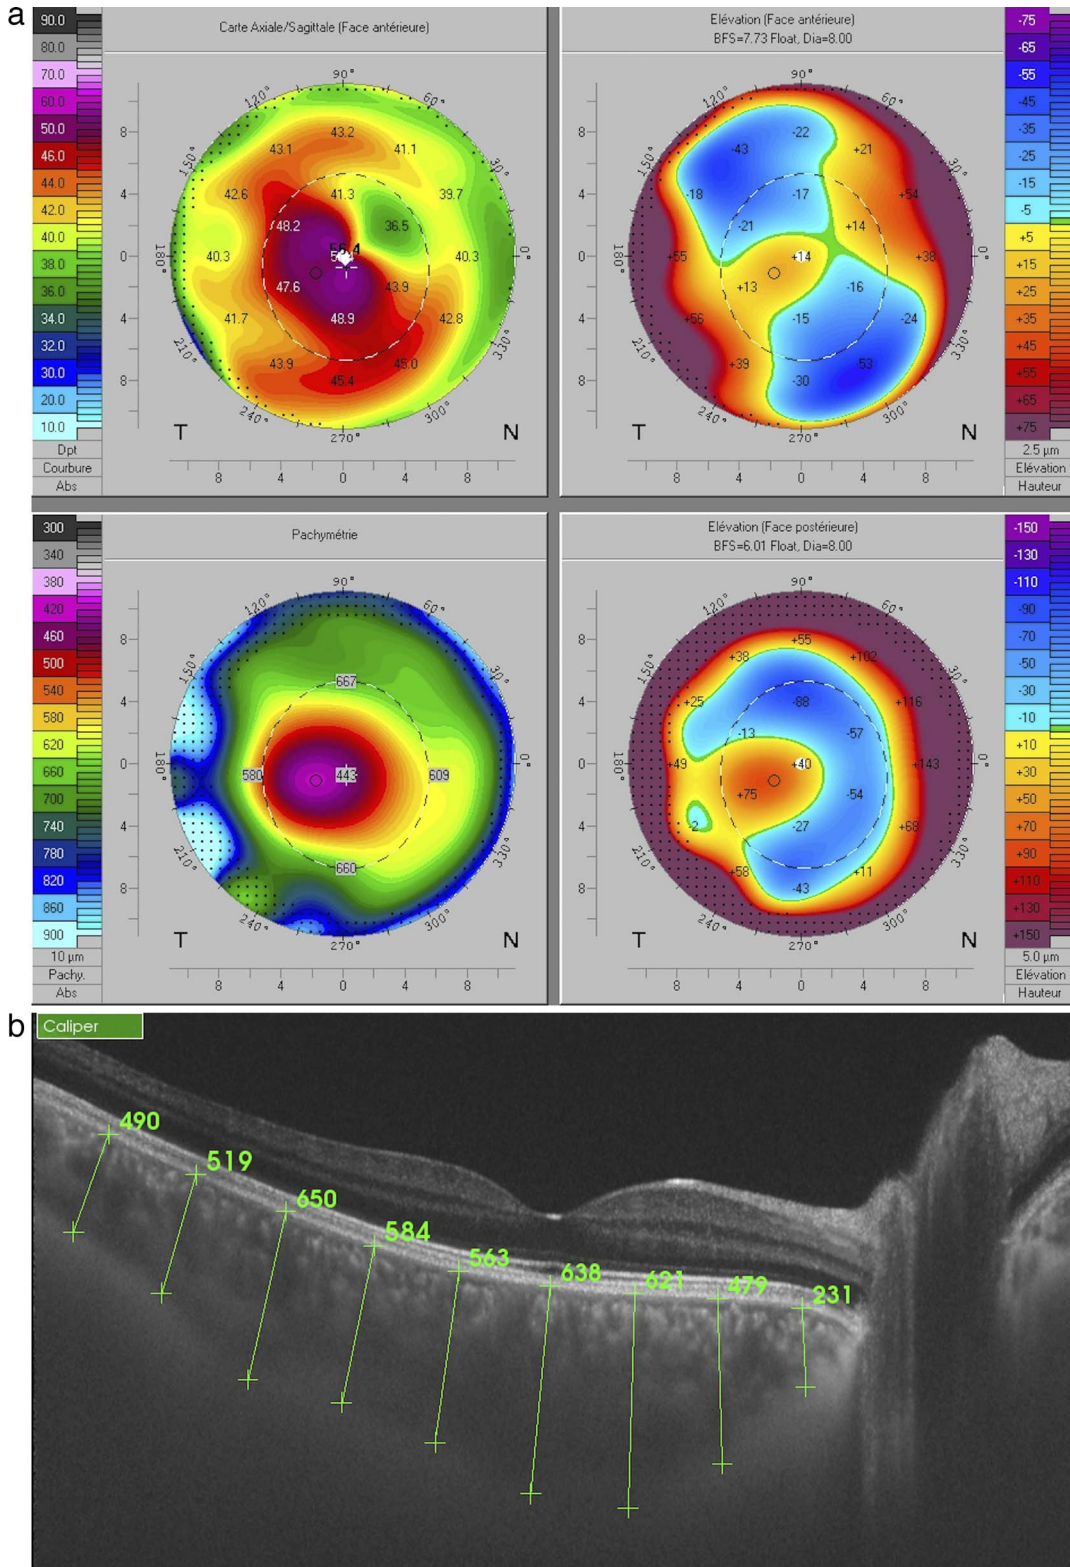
Corneal topography map from both right (grade II KC, a) and left eye (grade I-II, c) of patient with initials ATL provided by Pentacam and including the axial (*top left*) and pachymetric map (*bottom left*), and the anterior (*top right*) and posterior elevation (*bottom right*) of the cornea. Corresponding SS-OCT image of the same patient showing the measurements of CT of right (b) and left eye (d).
